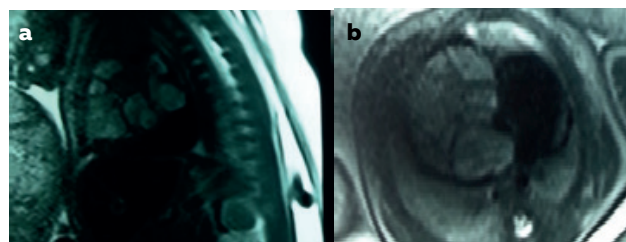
Coronal view of fetal cardiac MRI showing a heterogeneous mediastinal mass(a). Sagittal view of fetal cardiac MRI showing a large mediastinal mass with an intimate contact with the right heart cavities(b)
